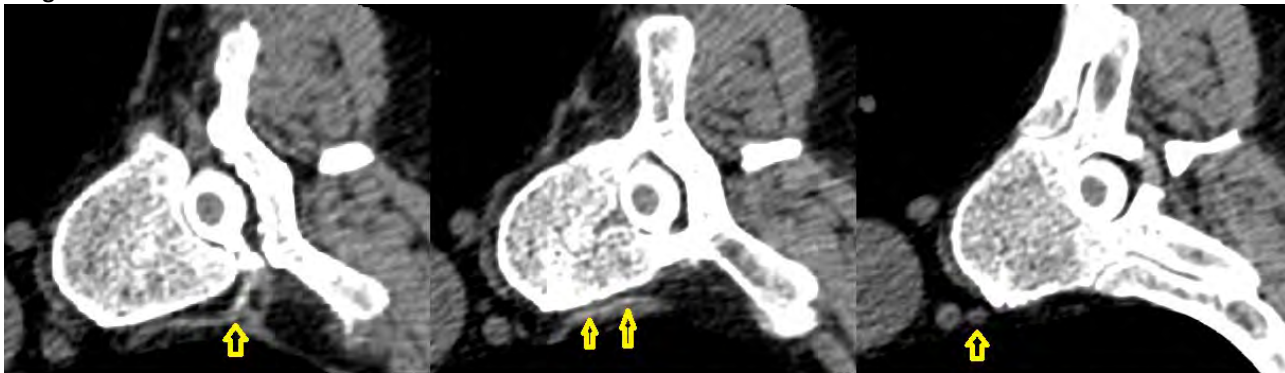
CT myelogram thoracic spine images at the T8-T9 level demonstrating myelographic contrast entering a right paraspinous vessel coursing towards the azygos vein, suggestive of CSF-venous fistula.
